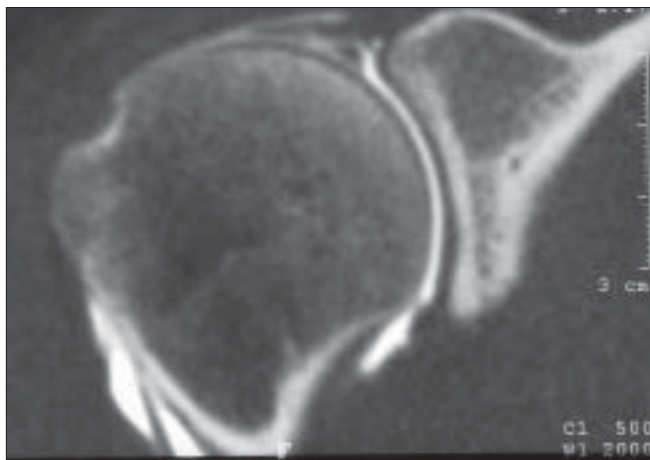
Arthro-CT scan. Coronal view showing a type II SLAP lesion
